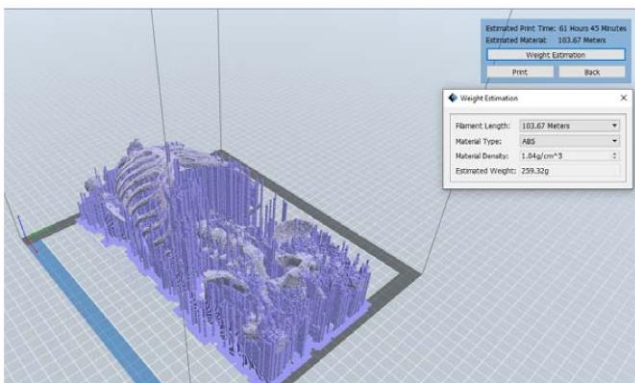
3D model Preview from thresholded CT data without filtering
